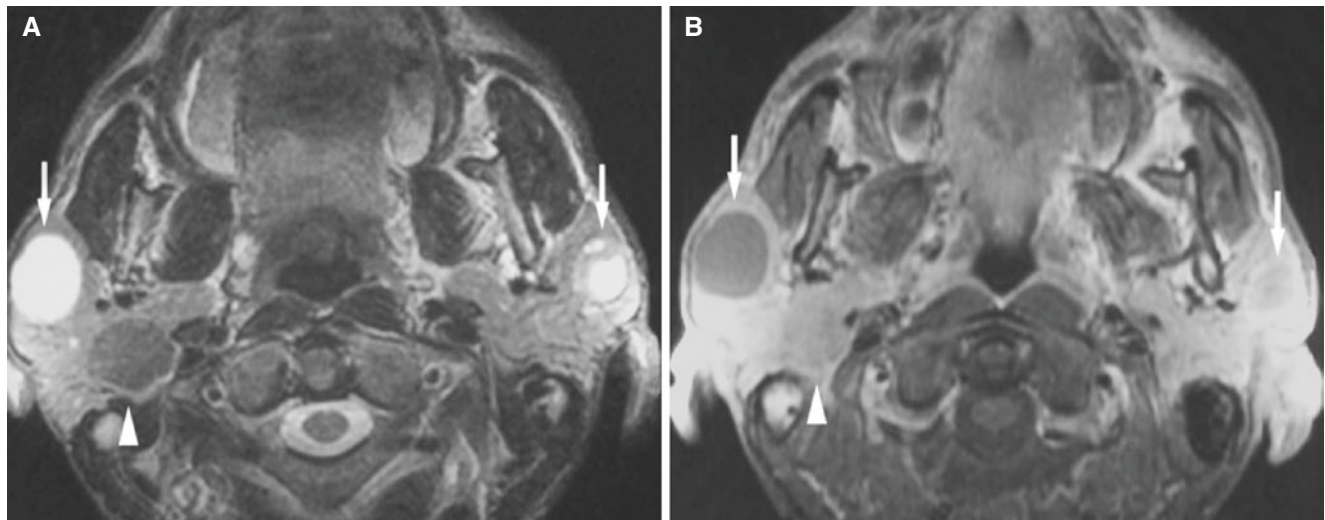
Benign bilateral lymphoepithelial cysts; 53-year-old male with AIDS presents with bilaterally enlarged parotid glands. (A) Axial T2-weighted fat-suppressed MRI shows bilateral fluid-filled cysts
